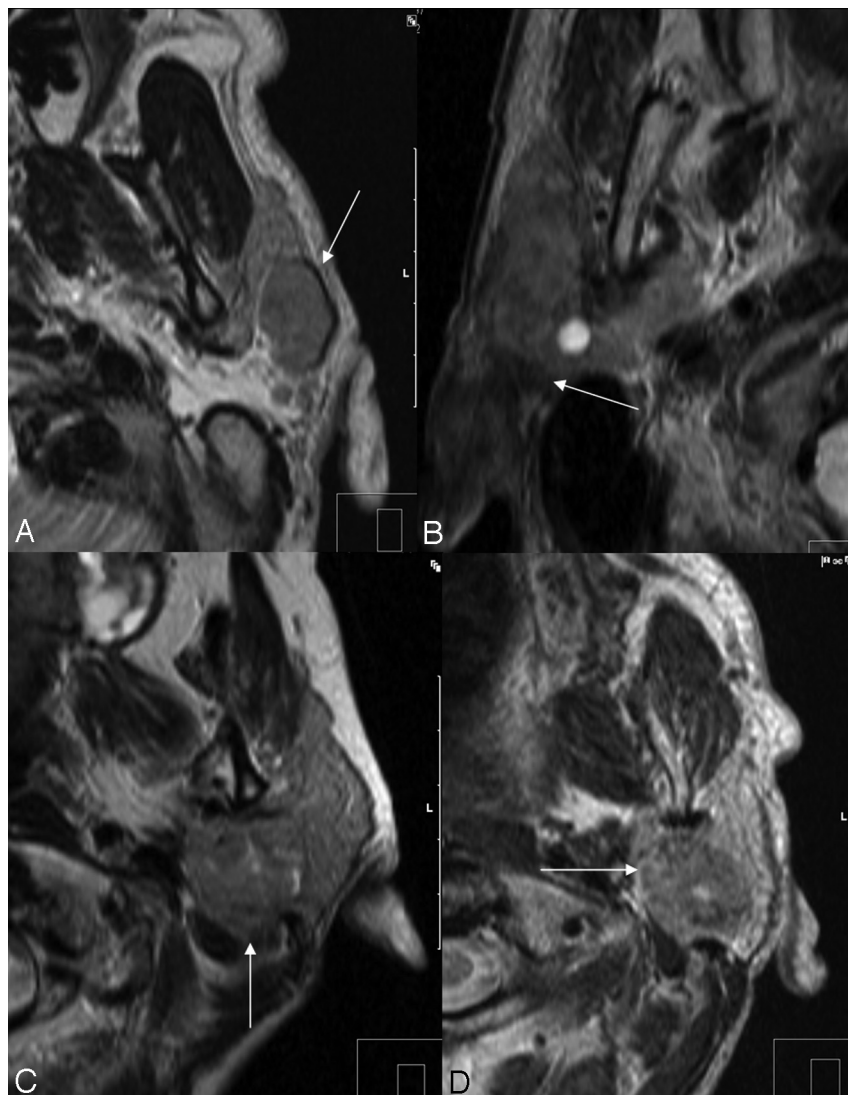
Low SI on axial T2-weighted images as a sign of malignancy. *A*, Non-Hodgkin lymphoma of a 44-year-old male patient. *B*, A 76-year-old man with parotid infiltration of a squamous cell carcinoma of the skin. *C*, Myoepithelial carcinoma of a 54-year-old female patient in the deep parotid lobe. *D*, Adenoid cystic carcinoma of a 54-year-old woman.
